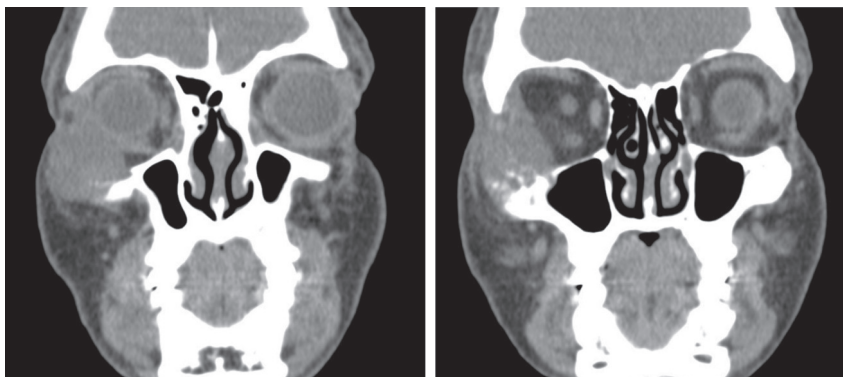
Side-by-side CT coronal images which demonstrate an expansile soft-tissue and osteolytic lesion involving the right zygoma and orbital space.
